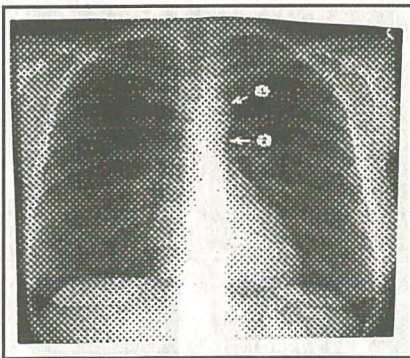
A thoracic radiograph. Found at the Radiology Atlas site.
